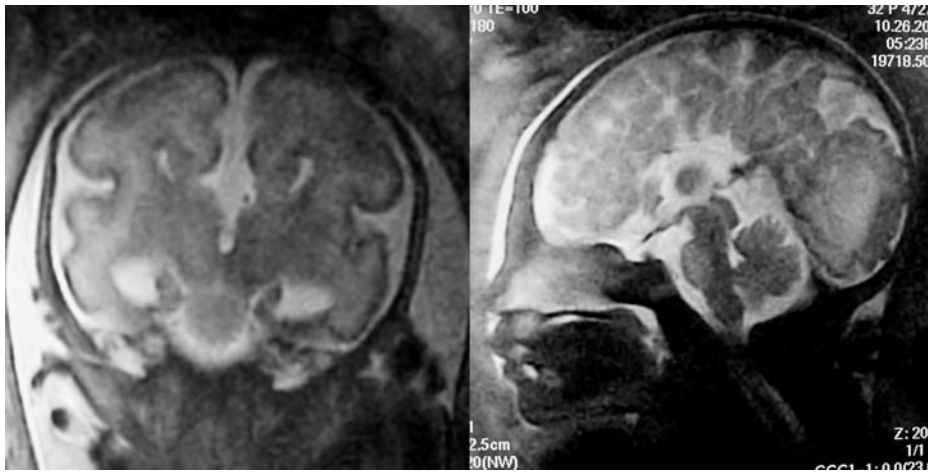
Fetal MR images of complete agenesis of the corpus callosum at 33 weeks of gestation. Anterior coronal section (left) and median section (right). No communicated bridge is seen. Note the bull's horn like appearance of the anterior horns of lateral ventricle in the coronal image.
